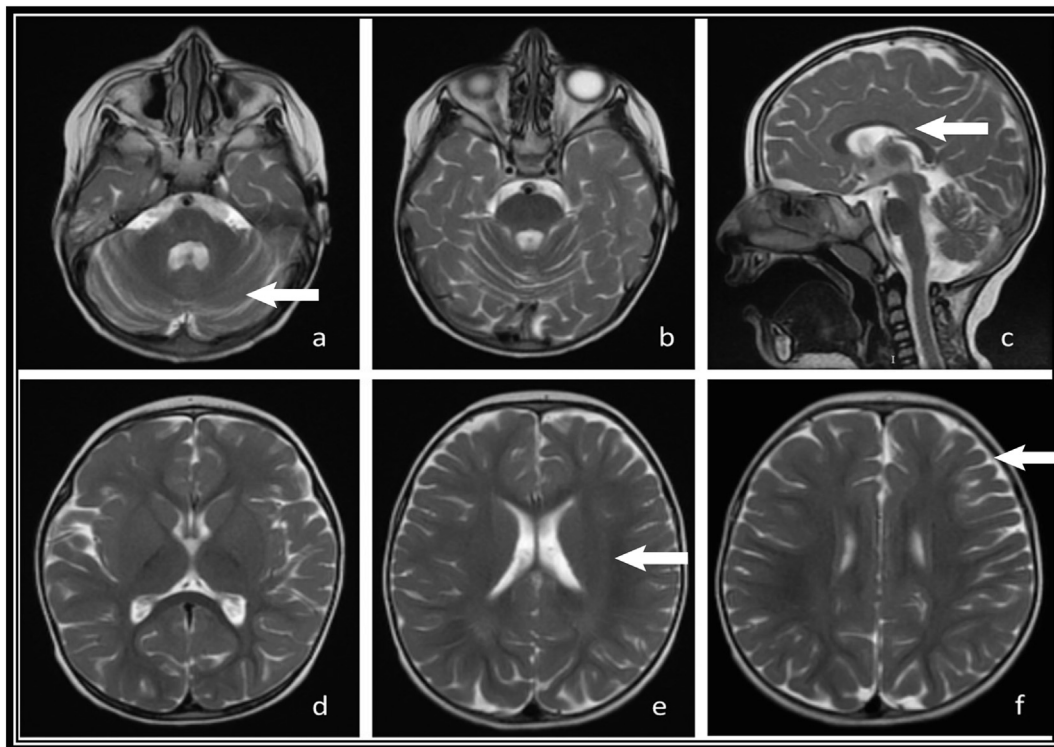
Patient 4 – T2-weighted axial sections (a, b, d, e, f) and T2-weighted sagittal section (c) from an MRI scan taken during the asymptomatic stage from this patient with an affected sibling. These sections show mild cerebellar atrophy (a), thinning of the corpus callosum (c), linear hyperintensity of central white matter (e) and mild cerebral atrophy (f).
